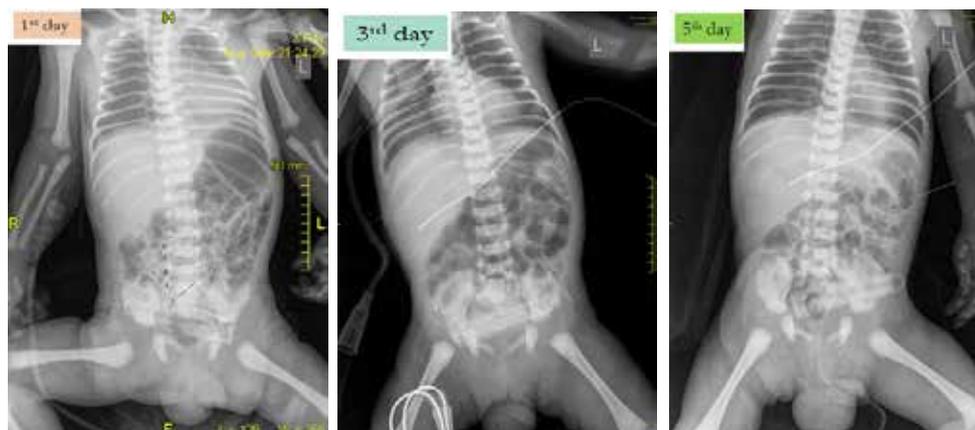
Abdominal imaging radiographs were done on second day of multi-modal 3 component enteral NEC prophylaxis scheme prescription, and were repeated on 3rd and 5th days
